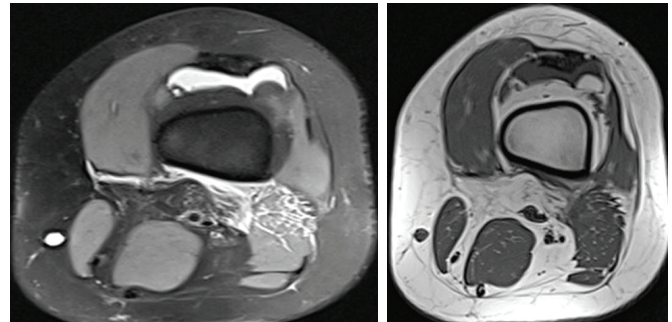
(Biceps femoris muscle injury): PD axial & T1 axial MR image in a 19-year-old male football player shows edema in biceps femoris muscle with fluid collection in suprapatellar recess.
